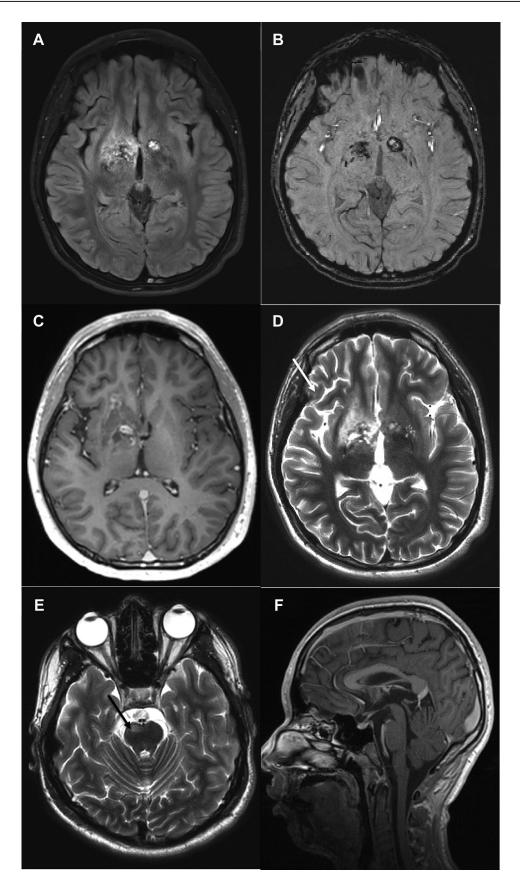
Baseline MRI in a 14-year-old boy with progressive cognitive decline, behavioral changes, and left hemiparesis. Axial FLAIR image demonstrates FLAIR hyperintense lesions in the bilateral basal ganglia (A) with associated signal abnormality on axial SWI image indicating iron or hemosiderin (B). The right basal ganglia lesion demonstrates abnormal
